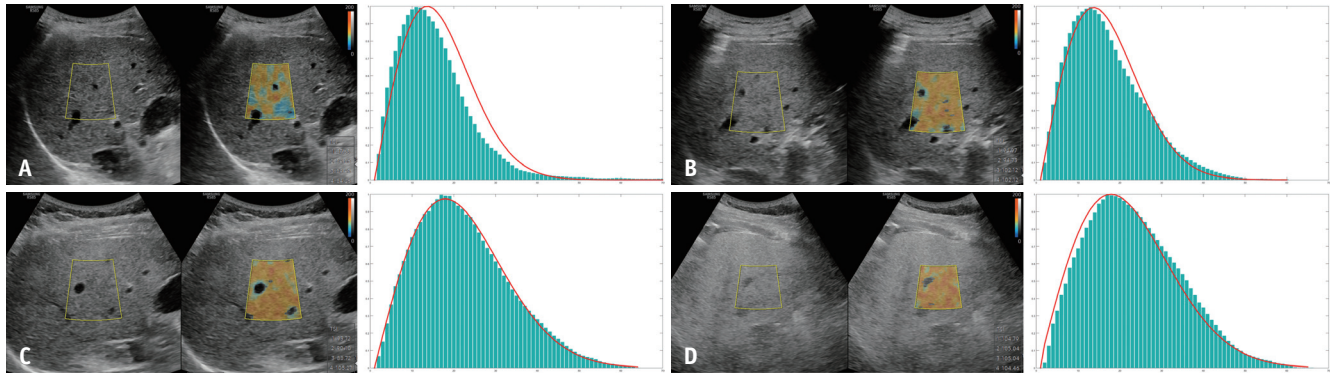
A commercialized quantitative ultrasound technique based on Nakagami distribution-TSI (Samsung Medison).
